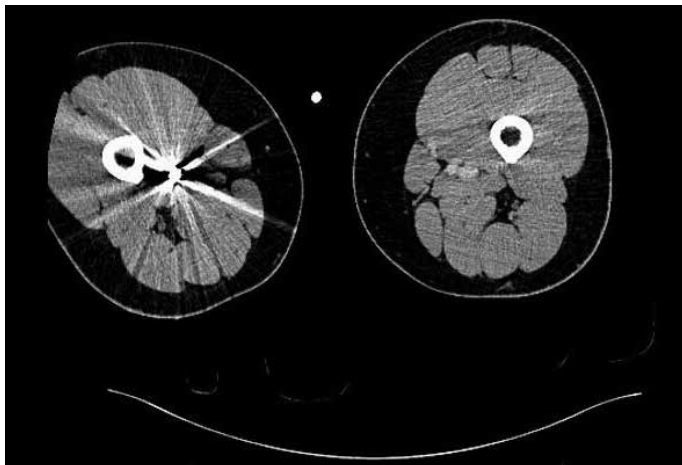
Computed tomography of the first localization of the bullet
